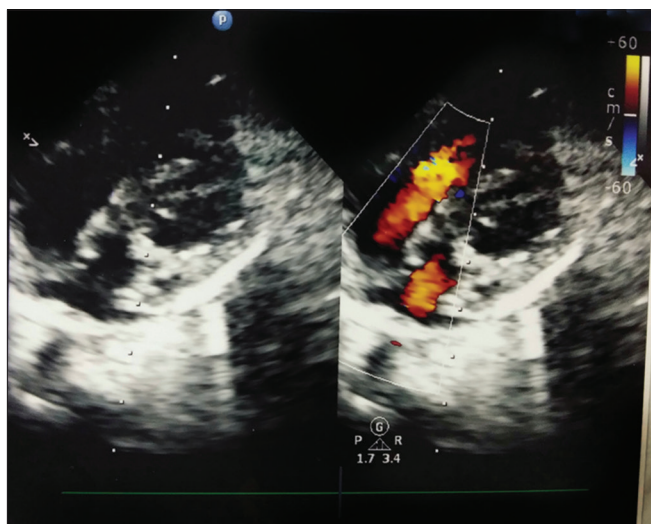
Echocardiography: Tetralogy of Fallot, Small pulmonary artery, small RVOT
